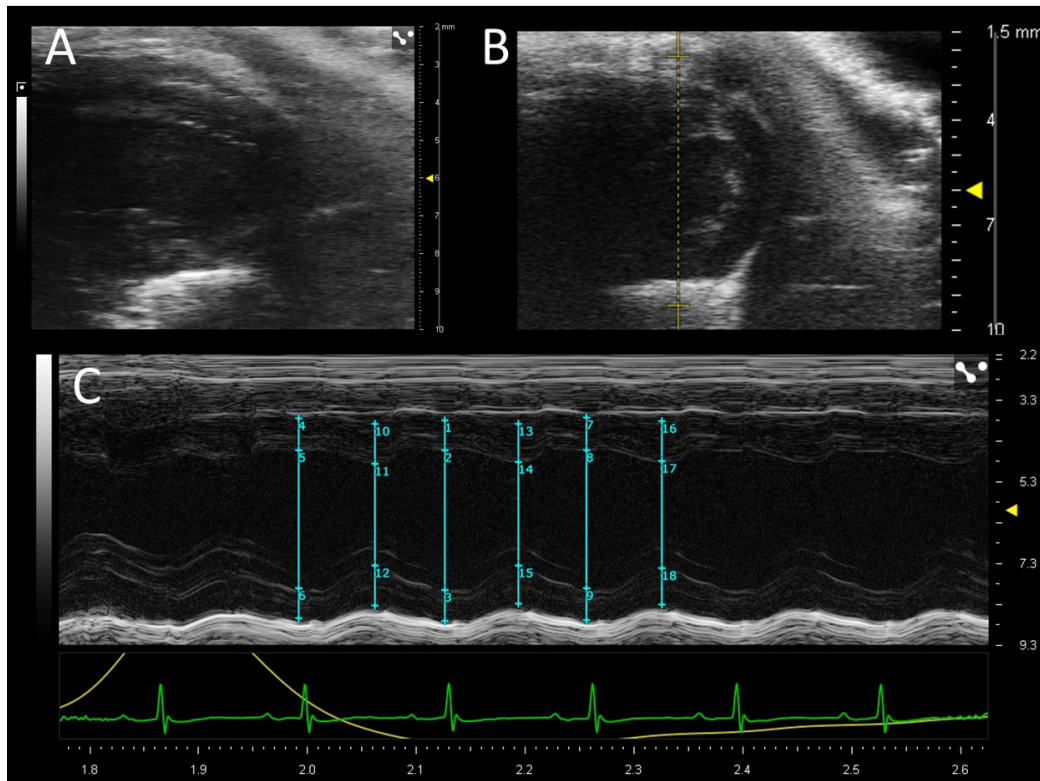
A) Representative echocardiography Long-axis view B) short-axis view with line marking the M-mode measurement C) M-mode, 3 consecutive measurements of systolic and diastolic diameters in short-axis
